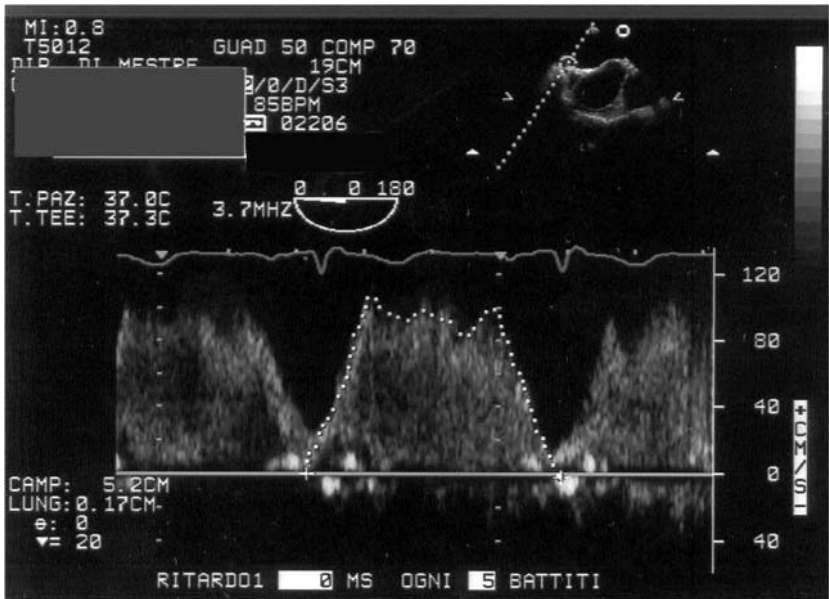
Doppler flow of a critically stenosed pulmonary vein. The spectrum shows a 'plateau' configuration
